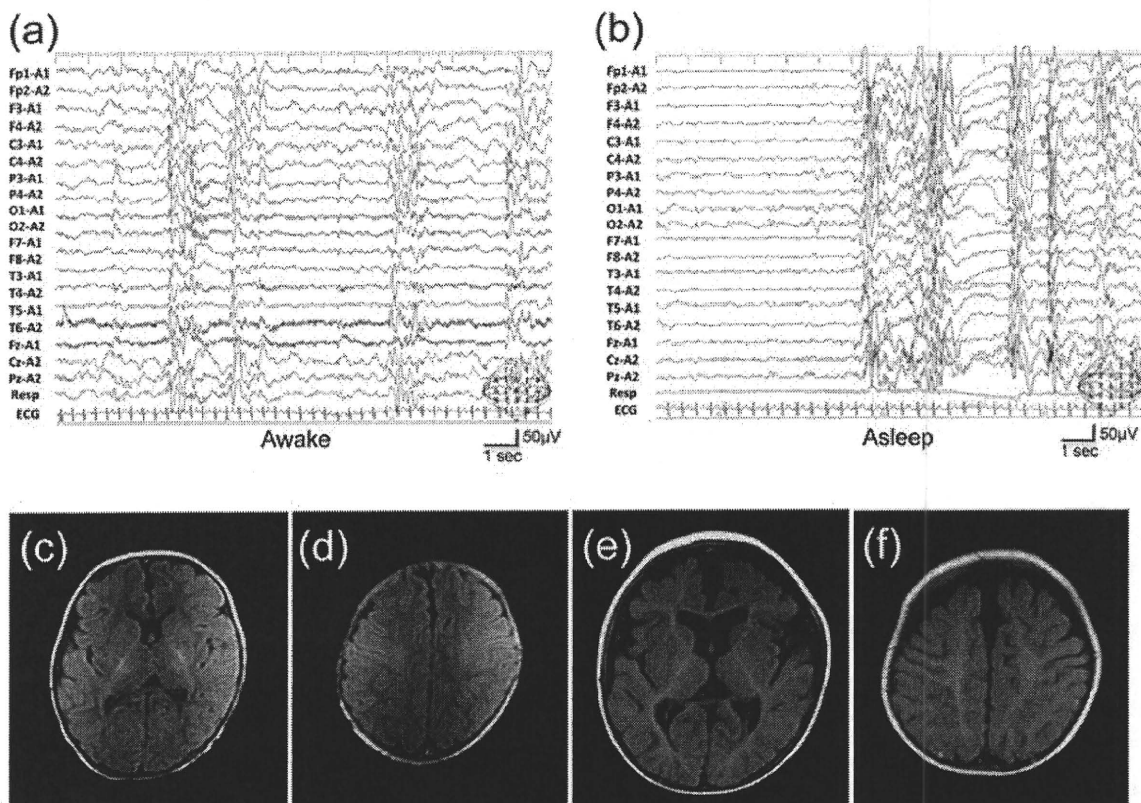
Interictal electroencephalogram (EEG) (a, b) and brain magnetic resonance imaging (MRI) (c–f) of the patient. EEG during both waking (a) and sleep (b) at 1 month of age showed suppression-burst pattern consisting of low-voltage, almost flat phase and high-voltage paroxysmal activity phase. Brain MRI showed normal findings at 1 month of age (c, d), and slightly dilated lateral ventricles at 11 months of age (e, f) because of adrenocorticotropic hormone injection.
